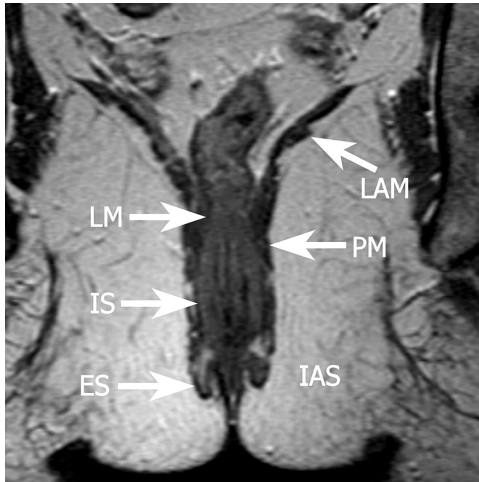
Coronal T2- weighted fast spin-echo (2500/70) external phased array MR image through the anal canal shows normal anatomy of the sphincter complex. It is difficult to make a reliable differentiation between the longitudinal muscle (LM) and external anal sphincter (ES) muscle as either are hypointense. The internal anal sphincter (IS) is isointense to hypointense. Figure 18 concerns the same patient as Figure 16. IAS = ischioanal space, PM = puborectal muscle, LAM = levator ani muscle
